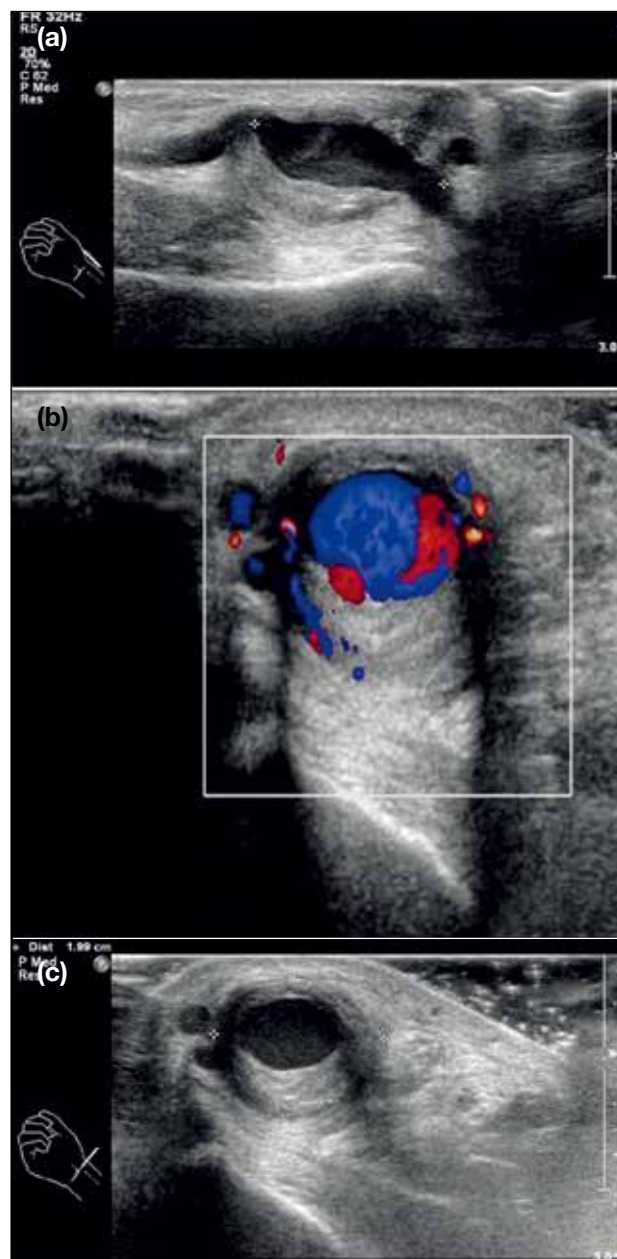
Pseudoaneurysm of the radial artery in a 49-year-old man who presented with right wrist mass after injury: (a) Ultrasound image of the right wrist in the longitudinal plane showing an elongated hypoechoic lesion. (b) The same lesion in the transverse plane shows an eccentric peripheral hyperechoic component, suggestive of thrombus formation. (c) Colour Doppler revealed arterialised flow and it appears in continuity with the radial artery (not shown).
